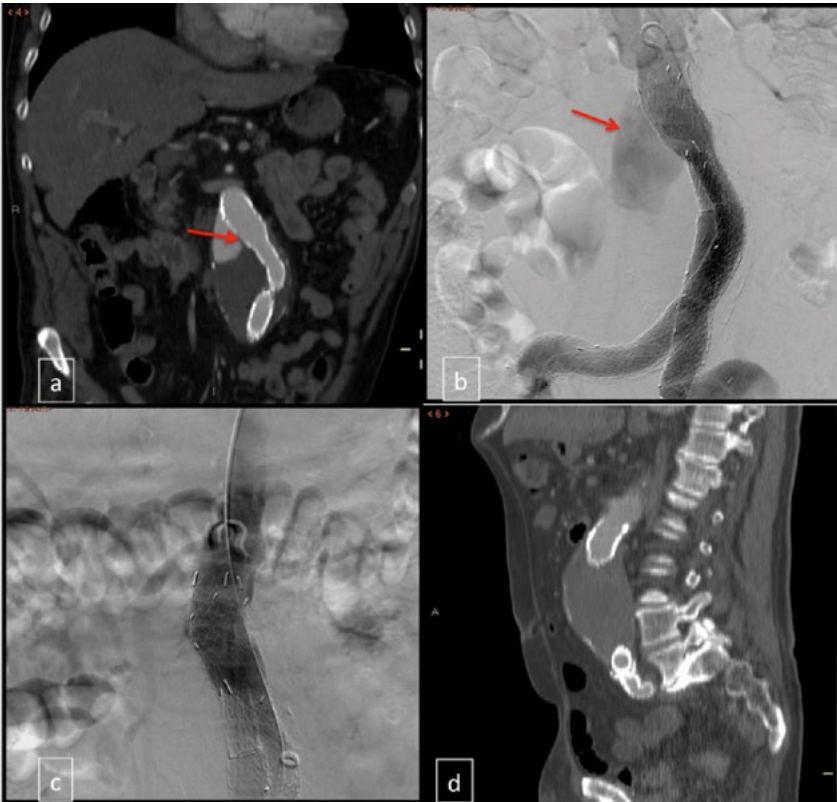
Endoleak type Ia on CTA (a) and DSA (b), management with proximal cuff extension (c) and disappearance of endoleak on control CTA (d).
